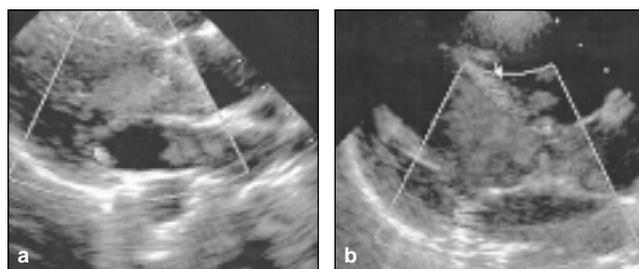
(a). Long axis view showing mild mitral regurgitation on color Doppler echocardiography. (b) Apical 4-chamber view showing mild mitral regurgitation on color Doppler echocardiography.
